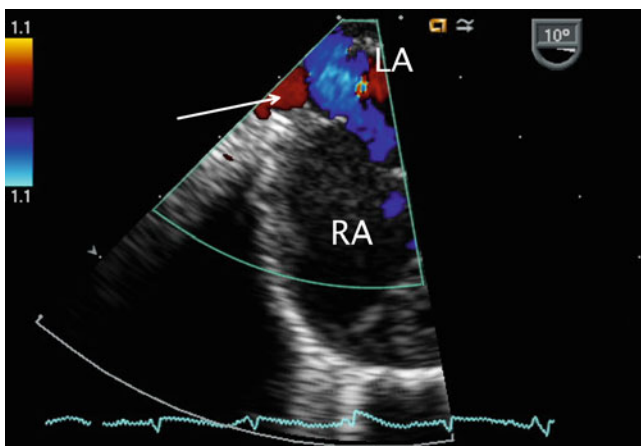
Color flow Doppler in a similar plane as shown in Fig. 7.9 to assess drainage of the right upper pulmonary vein (red color flow shown by *arrow*) into the left atrium (*LA*). *RA* right atrium
